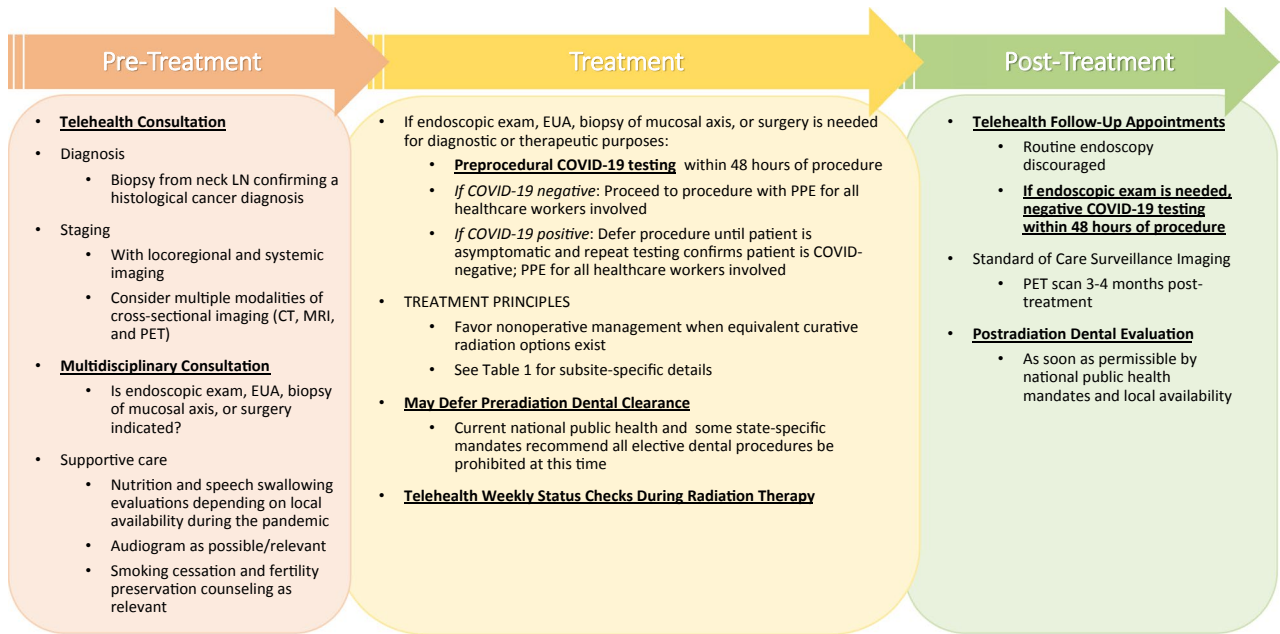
Incorporating telehealth and COVID-19 precautions into cancer care during the pandemic: preflight checklist. COVID-19 indicates coronavirus disease 2019; CT, computed tomography; EUA, examination under anesthesia; LN, lymph node; MRI, magnetic resonance imaging; PET, positron emission tomography; PPE, personal protective equipment.
